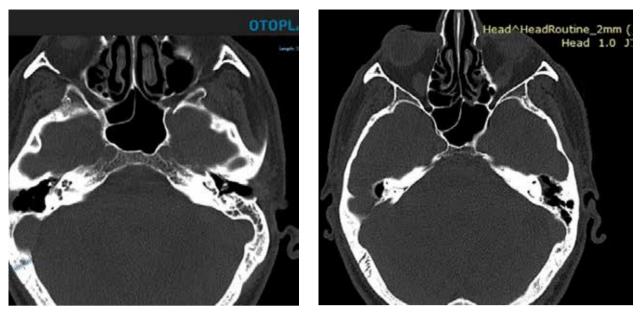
№2A and Fig. №2B. CT scan of the patient D.T. before implantation
